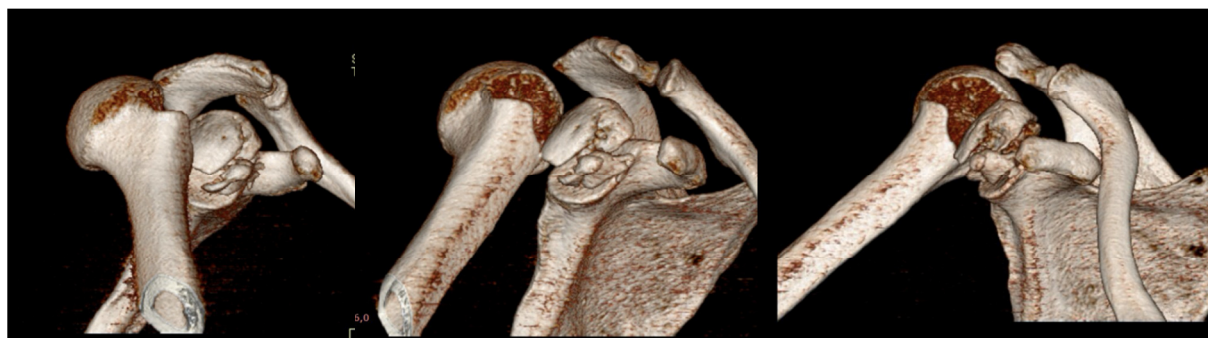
Computed tomographic 3D reconstruction findings demonstrate the more clearly identifiable posterior shoulder dislocation and greater tuberosity fracture.
